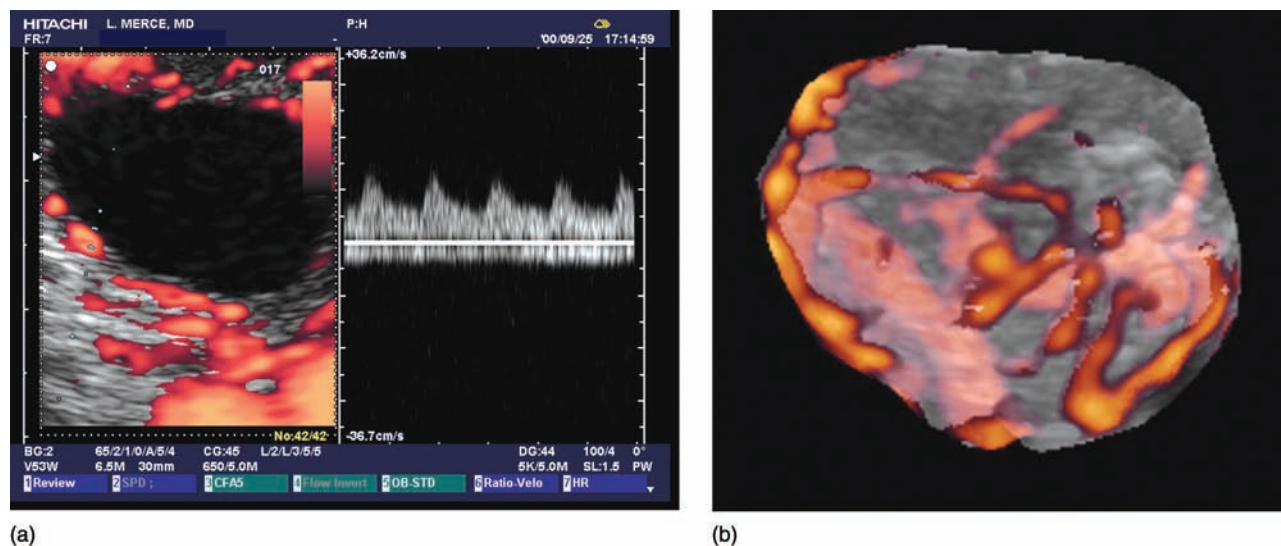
Study of the preovulatory follicle blood flow by Doppler technology. (a) Color signal and FVW arterial and venous in the wall of a 20 mm follicle. Look at the absent pulsatility of the venous signal. (b) Vascular network of a preovulatory follicle by 3D power Doppler angiography.
